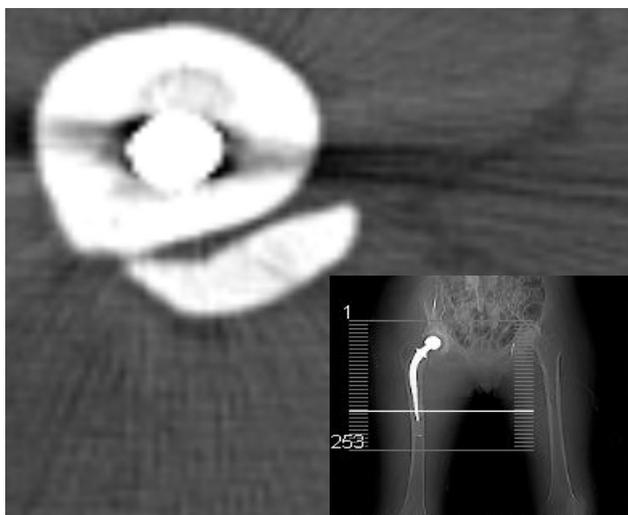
CT of right femur showing extracortical cement
